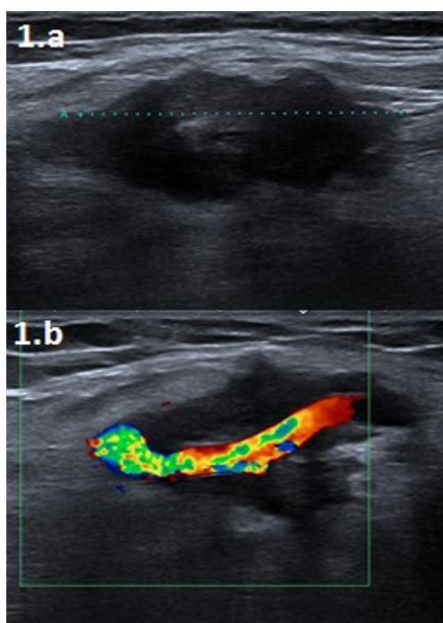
B-mod and colour Doppler ultrasound images (a and b) show an irregularly contoured soft tissue mass surrounding the brachial artery medially in the right arm midsection.
